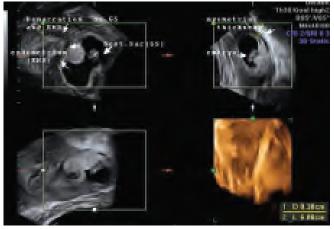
Three-dimensional ultrasound provides views of the uterus, which cannot be obtained by conventional 2D ultrasound scan. Coronal section (upper left image) and surface rendering (lower right image) enable visualization of the cornual ectopic pregnancy
